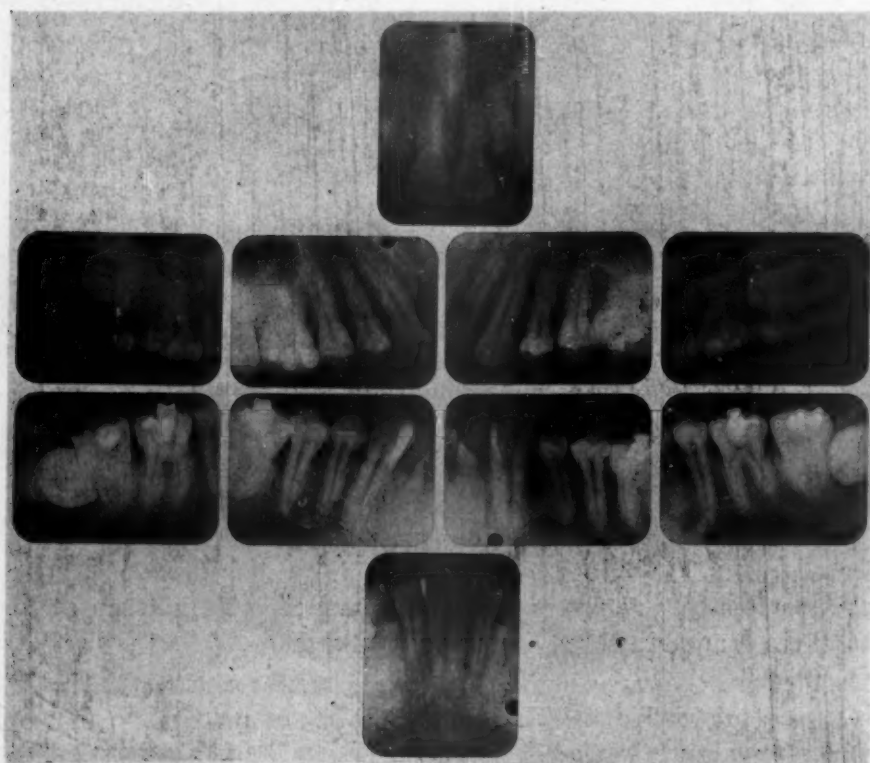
X-rays of teeth of H. G., taken Aug. 14, 1940, after treatment.
